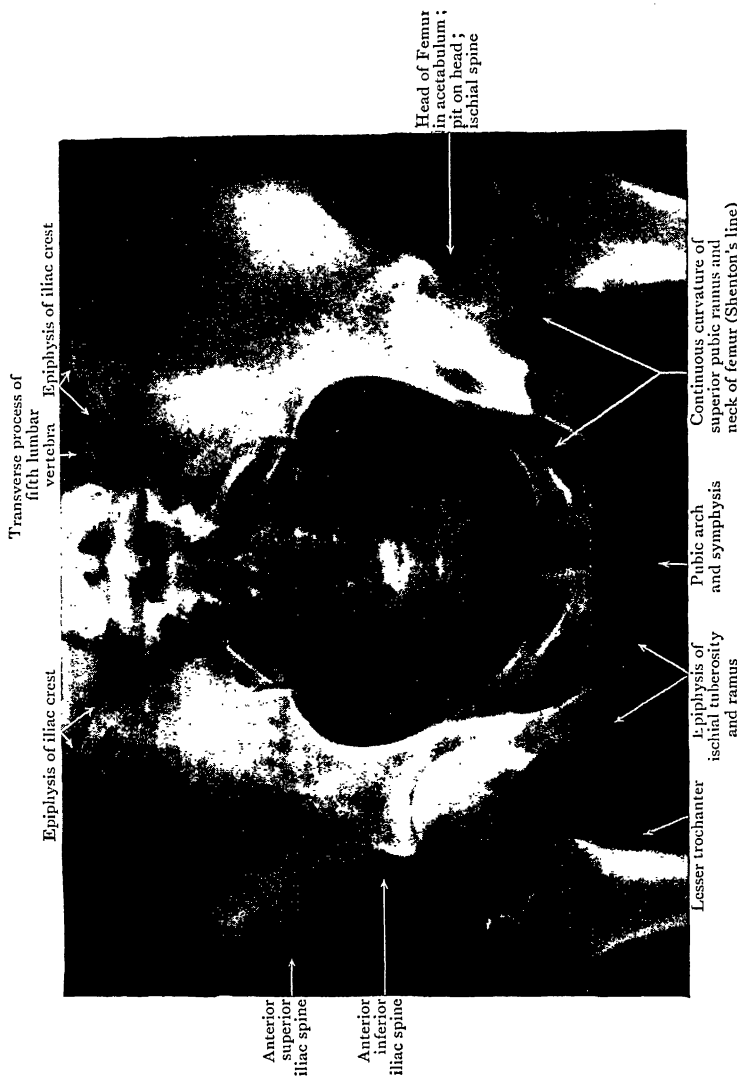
Radiograph of Female Pelvis (girl aged 17).
